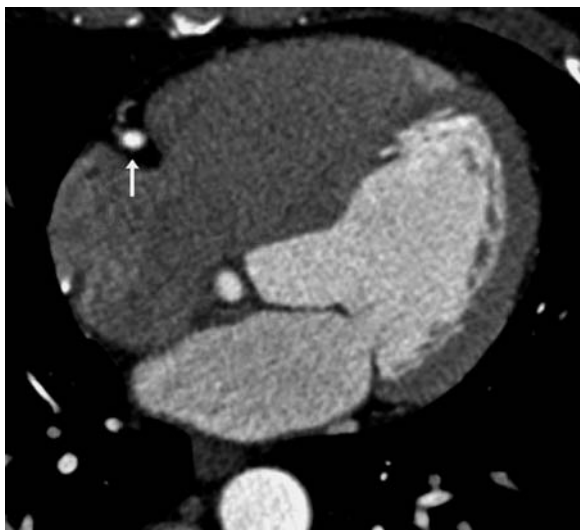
In a 16-row-detector CT complete and homogenous enhancement of the left ventricle and the coronary arteries can be achieved by a dedicated contrast protocol. The contrast medium has passed the right ventricle and the flush with saline results in a washout of the contrast medium from the right ventricle (arrow)
